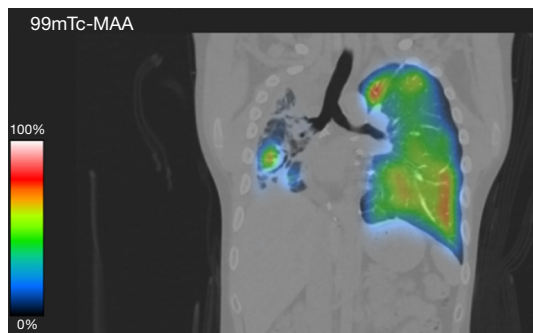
Representative image of unilateral CLAD after bilateral living-donor lobar lung transplantation. Lung perfusion scintigraphy demonstrates a perfusion shift to the left unaffected lung in a patient with right unilateral CLAD. CLAD, chronic lung allograft dysfunction.
